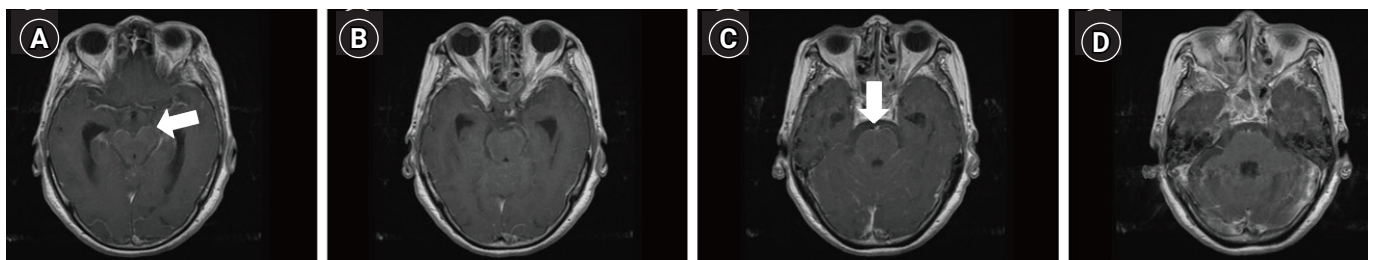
(A-D) Brain magnetic resonance imaging shows meningeal enhancement around brainstem with focal nodular enhancement (arrows).
